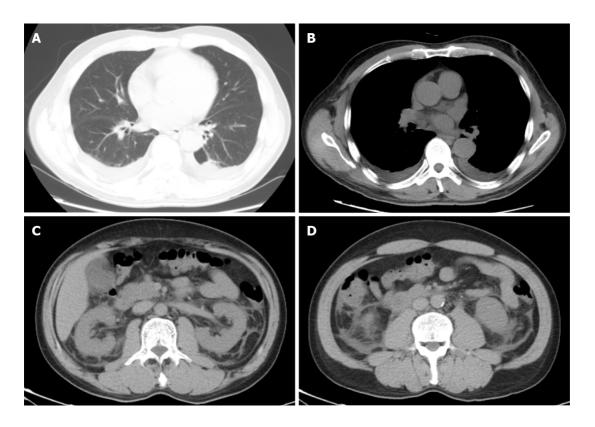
The computed tomography scan of chest and abdomen showed pleural effusion, perinephric effusion extended to paracolic sulcus, and slight peritoneal and pelvic effusion. A and B: Computed tomography of the thorax and abdomen on hospital day 1 showing pleural effusion; C and D: Perinephric effusion extended to paracolic sulcus and slight peritoneal and pelvic effusion.
